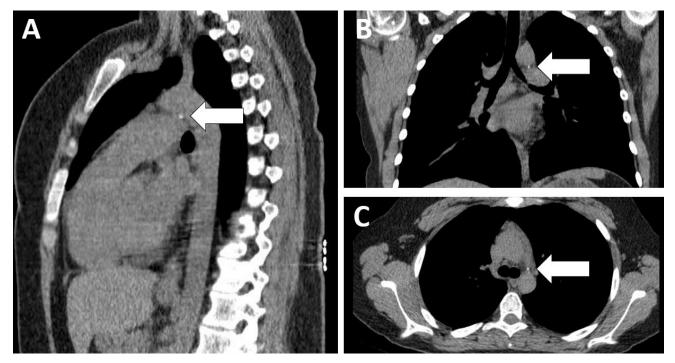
Demonstrating subtle-punctate calcification of the ligamentum arteriosum on non-contrast thorax CT; In the sagittal (A), coronal (B), and axial (C) sections of the unenhanced thorax CT of a 14 years and 7 months old female patient, subtle-punctate calcification (white arrows) is visible between the proximal descending aorta and the pulmonary artery.
